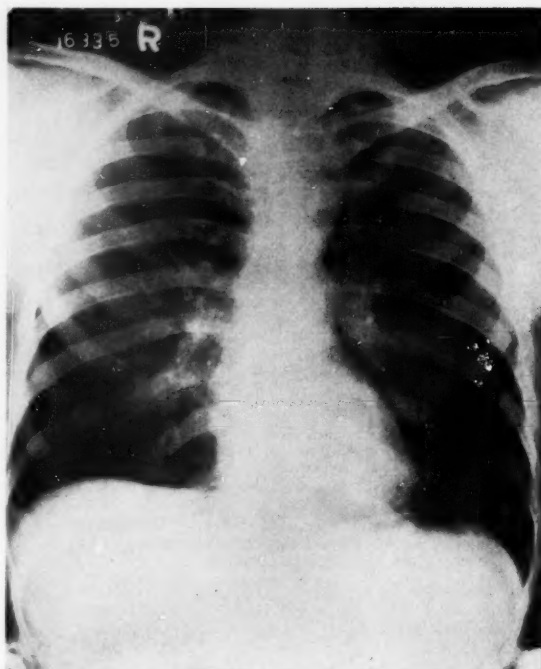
Chest x-ray of Case 3 (E. L. S.) on the 48th hospital day showing blunting of the right diaphragm with a slight pleural effusion.
